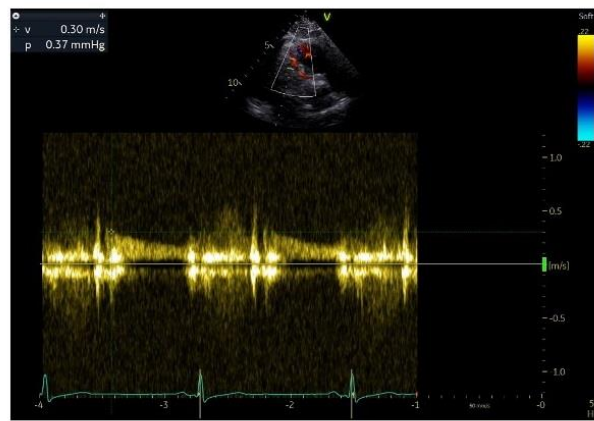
A typical color-flow appearance for a P-LAD: 2a from apical 5-chambers approach; 2b from 3-chambers approach; 2-c s pulsed-wave Doppler CFV envelope. The P tract goes from the aortic root approximately up to pulmonary valve, running over the interventricular septum and parallel to pulmonary artery. To obtain a good color-PW Doppler signal from P-LAD are needed about 2–3 minutes
